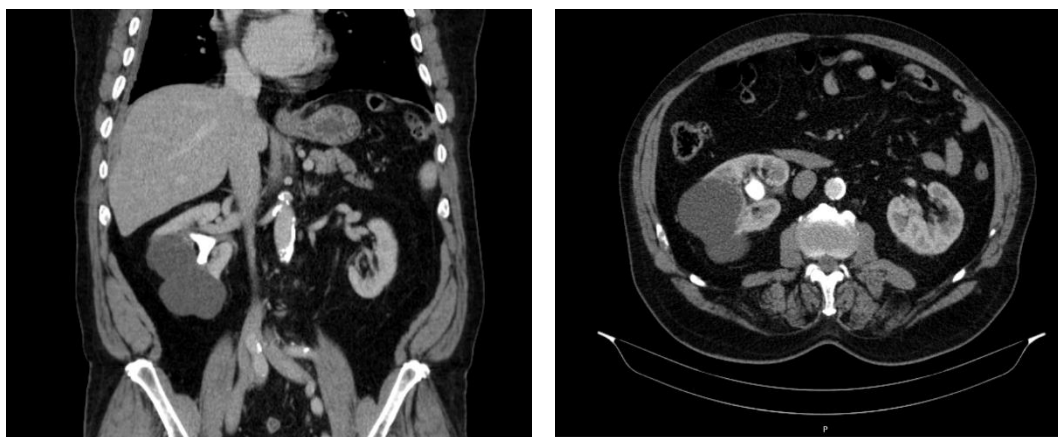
Abdominal CT scan: A) Coronal view, B) Transversal View
